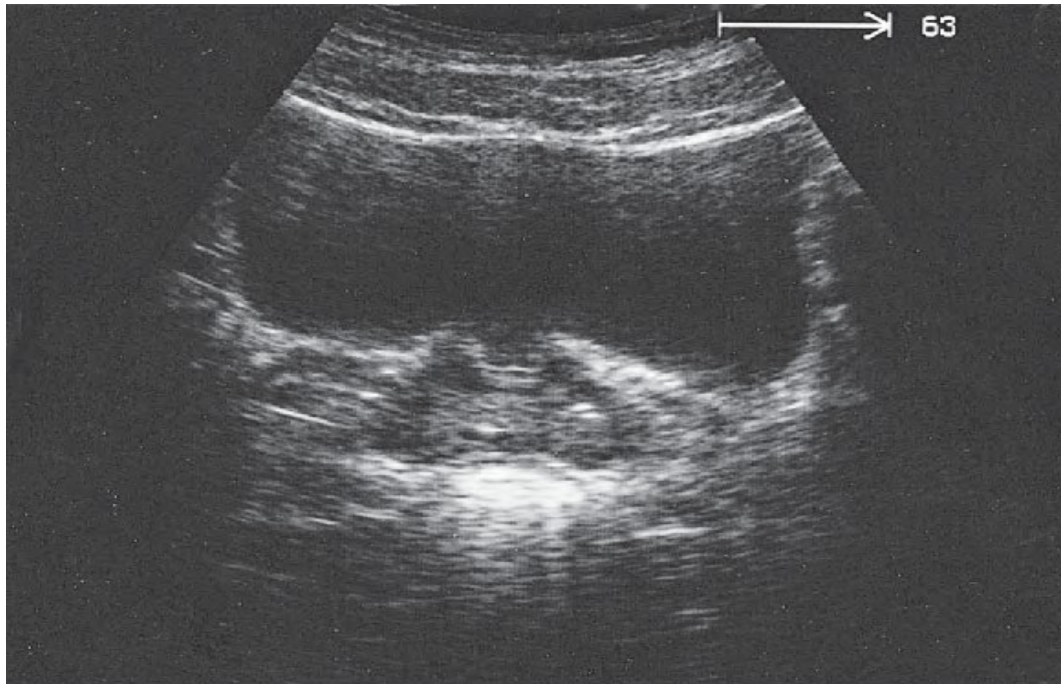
TAUS, longitudinal plane (above), and transverse plane (below), shows; normal prostate sonographic appearance (Block, 2004)
